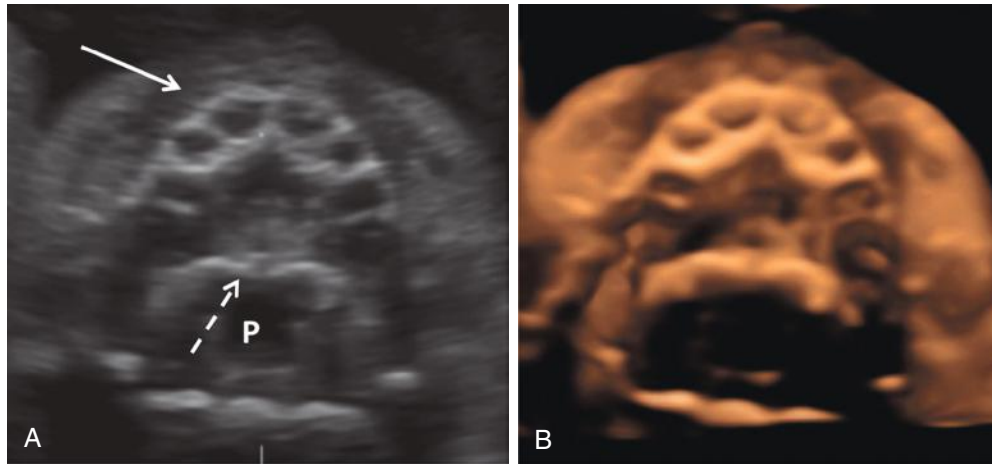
Normal palate at 24 weeks: A, Axial two-dimensional ultrasound image of normal palate showing toothbuds in the anterior alveolar ridge (*solid arrow*), posterior aspect of hard palate (*dashed arrow*), and pharynx (P). B, Axial three-dimensional ultrasound image of normal palate.
